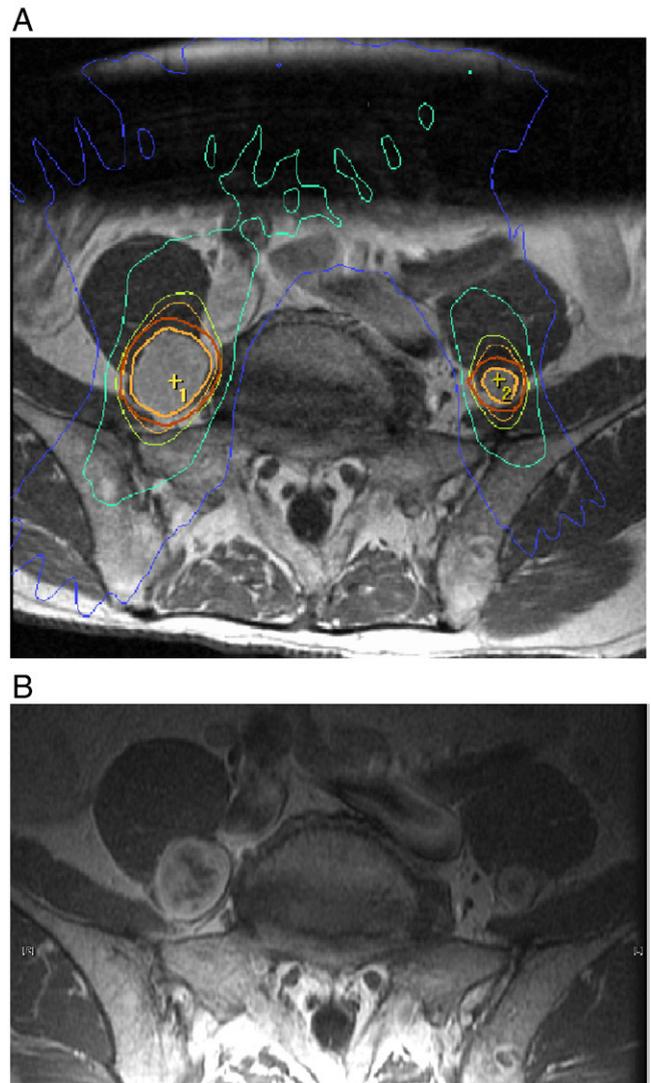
A: Axial contrast-enhanced MRI demonstrates 2 NFs at L4. Isodose lines displayed: 90% yellow, 80% (light green), 50% (teal), 30% (blue). The target (thick yellow) received 12 Gy prescribed at the 90% isodose encompassing the target plus a 2-mm margin (thick orange). B: Axial contrast-enhanced MRI 6 months after radiosurgery demonstrating loss of central contrast enhancement.
